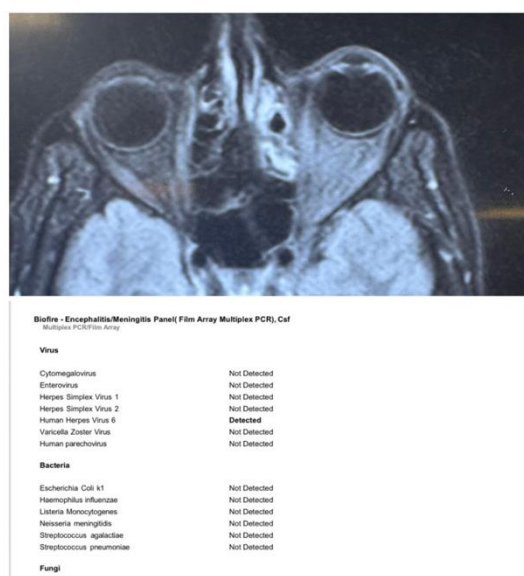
MRI showing Extensive Left optic nerve involvement with cavernous sinus thrombosis with HH6 positivity.
